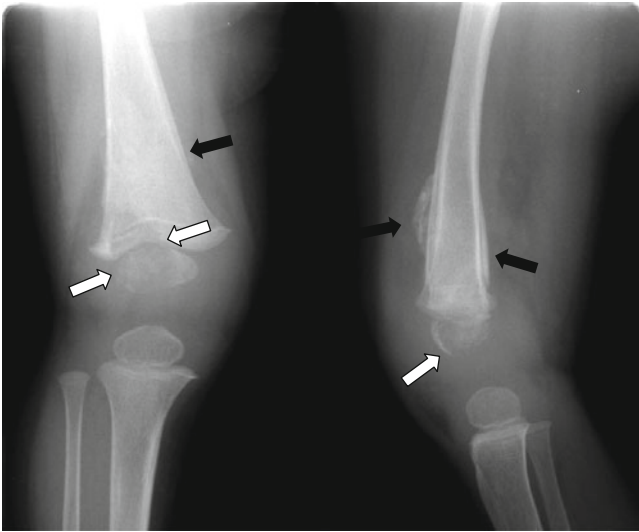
A 2-year-old girl with tuberculosis. Plain radiograph of the right distal femur demonstrates bone destruction (*white arrows*) and periosteal reaction (*black arrows*) (Courtesy of JE Cheon M.D., Seoul, Korea)
